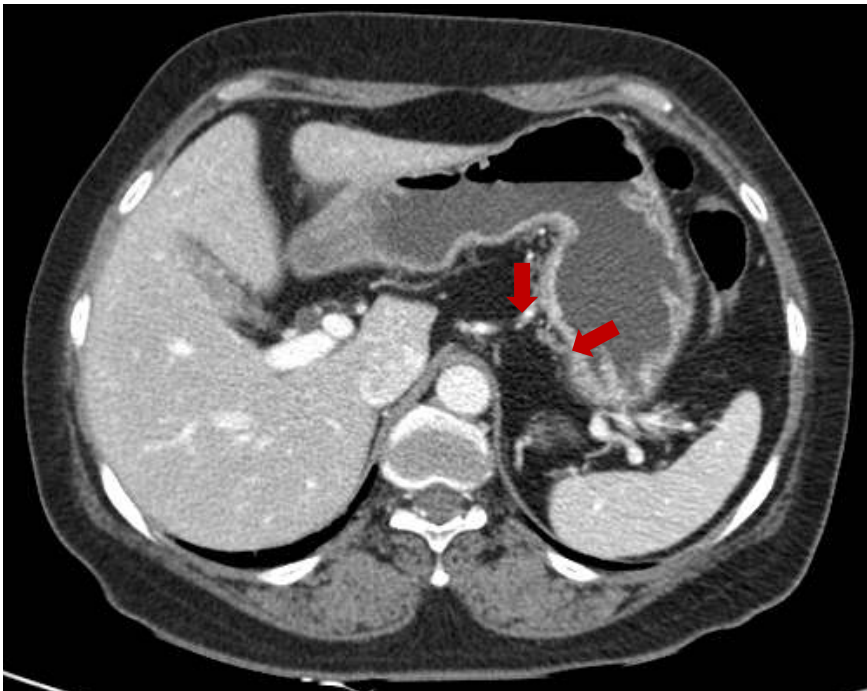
Multiple splenic aneurysms were observed on computed tomography during trauma evaluation (red arrows indicate the splenic aneurysm)
